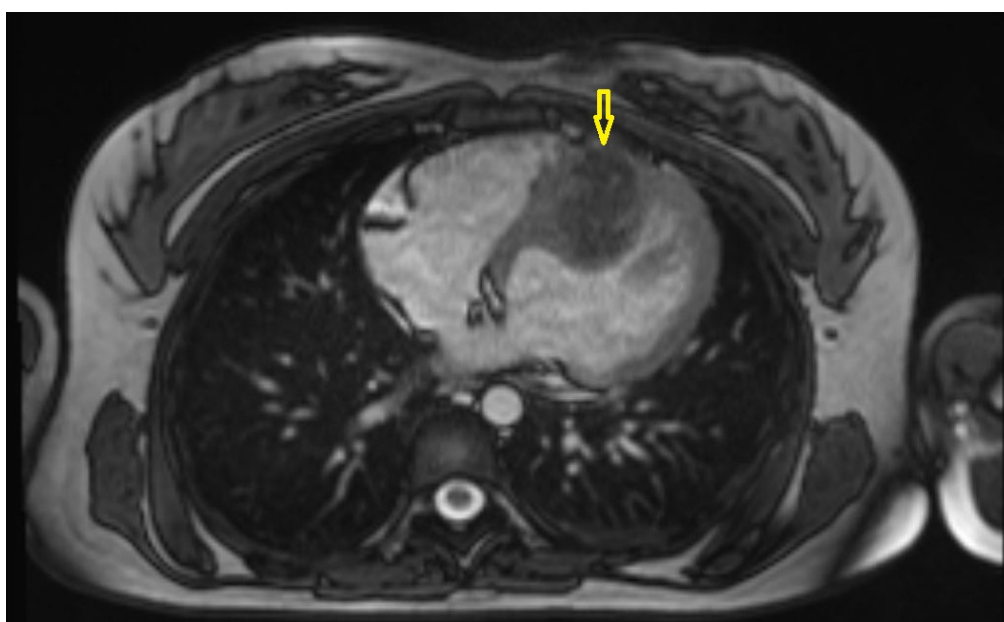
Representative cardiac magnetic resonance image from Case 3 obtained in the axial plane, demonstrating a large interventricular septal fibroma (arrow).
